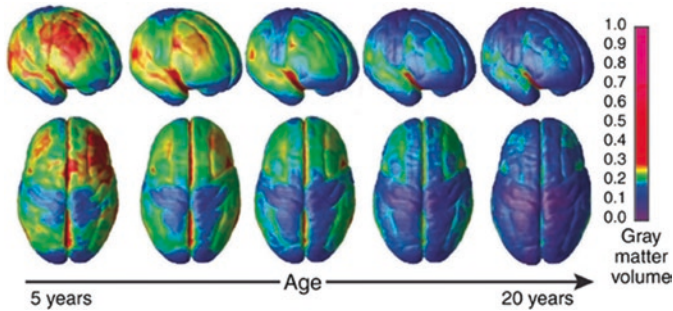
Grey matter development in human cortex. Anatomical MRI scans taken from 13 individuals age 4–21 were repeated at 2-year intervals to examine the development of the grey matter in their cortices. During maturation, the cortex grey matter thins due to the pruning of excessive synaptic connectivity. This process allows for the fine-tuning of neural circuits; with only neurons that are highly connected and active in functional circuits remaining, signals traveling along these circuits can be strengthened, while less active connections can be removed. The prefrontal cortex is the final cortical region to undergo this maturation process. In humans, this occurs during the third decade of life. [Reproduced from *Tau and Peterson 2009 (Copyright 2010) Neuropsychopharmacology* and *Gogtay et al (2004) (Copyright 2004) National Academy of Sciences, USA (Permission obtained from the Copyright Clearance Center's RightsLink® service)*]
